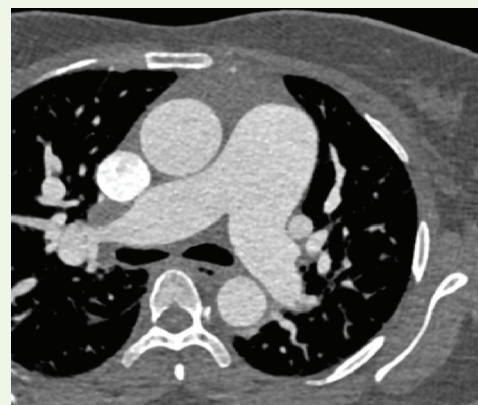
Axial contrast-enhanced CT image at the level of the pulmonary artery bifurcation demonstrating dilatation of the main pulmonary artery, suggestive of pulmonary hypertension.
